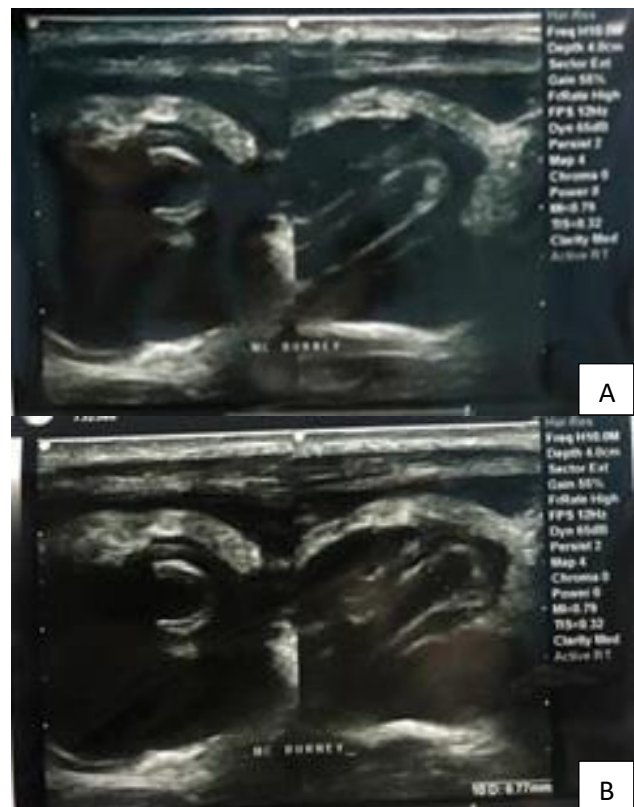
(A and B): Ultrasound of the Mc area of the abdomen, Burney.
